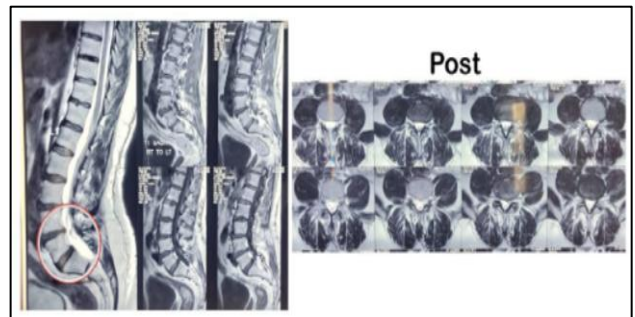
MRI findings: post-impression-August 2025.
